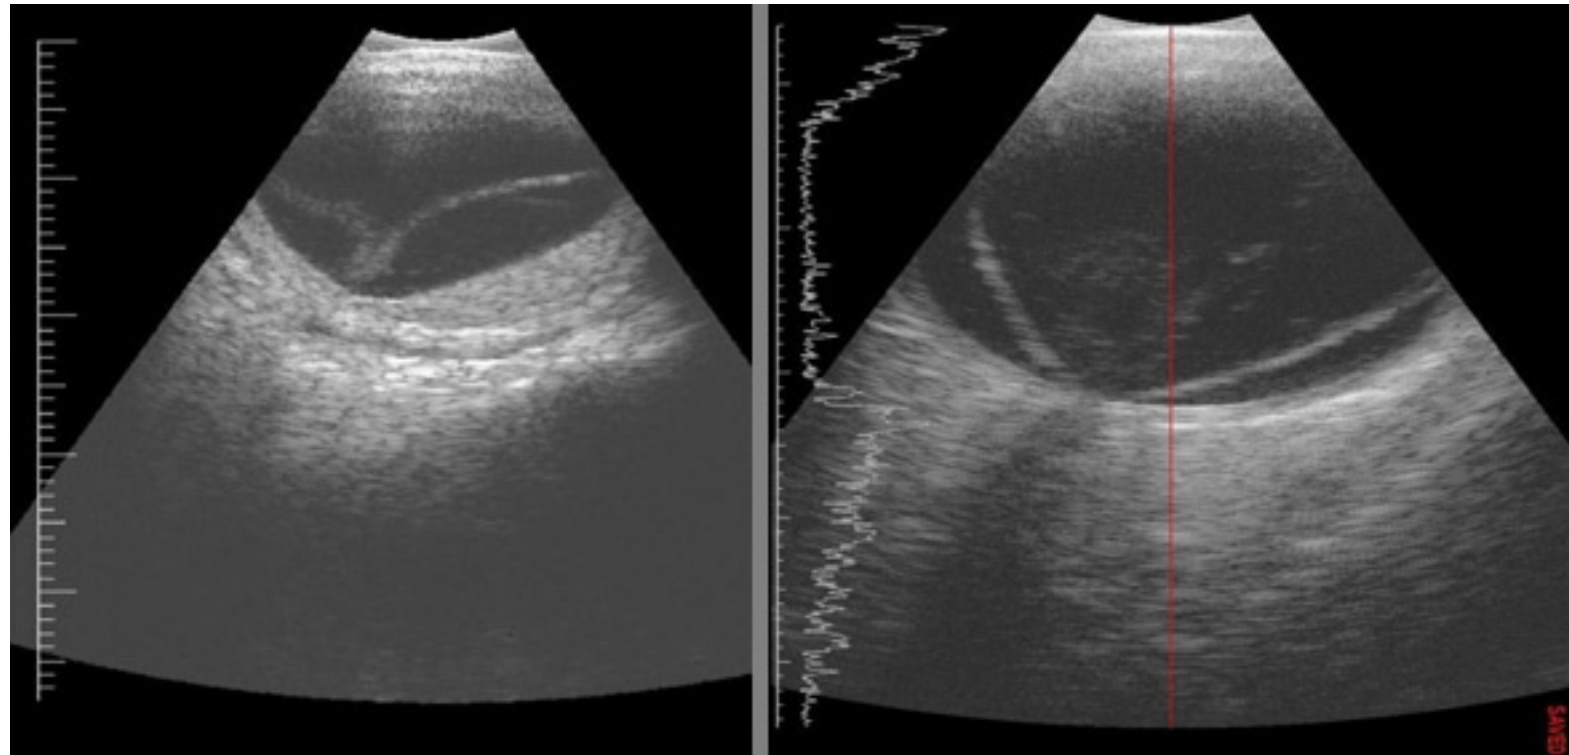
Ultrasound shows bilateral retinal detachment in 6 months baby with bilateral cataract
